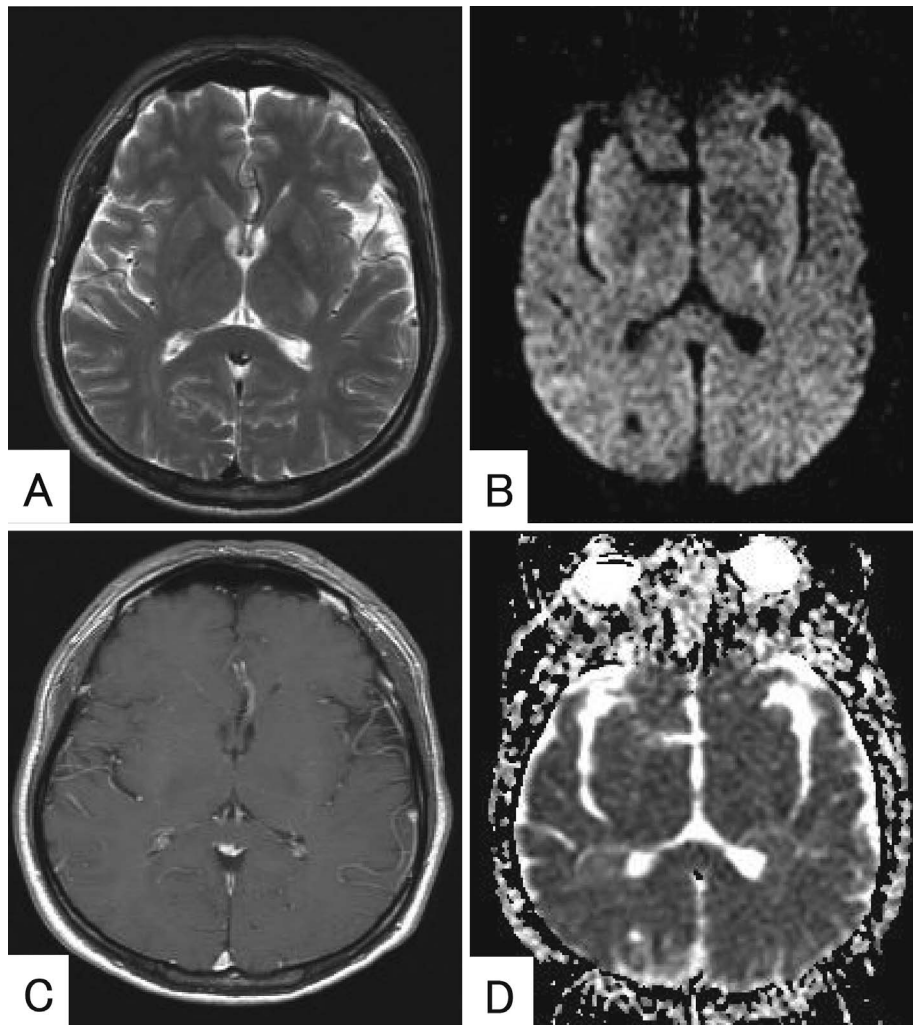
A focal area of high signal intensity on T2-weighted (A) and diffusion-weighted (B) MRI was noted in the posterior limb of the left internal capsule, which showed no gadolinium enhancement (C) and no decrease in the apparent diffusion coefficient (D).
